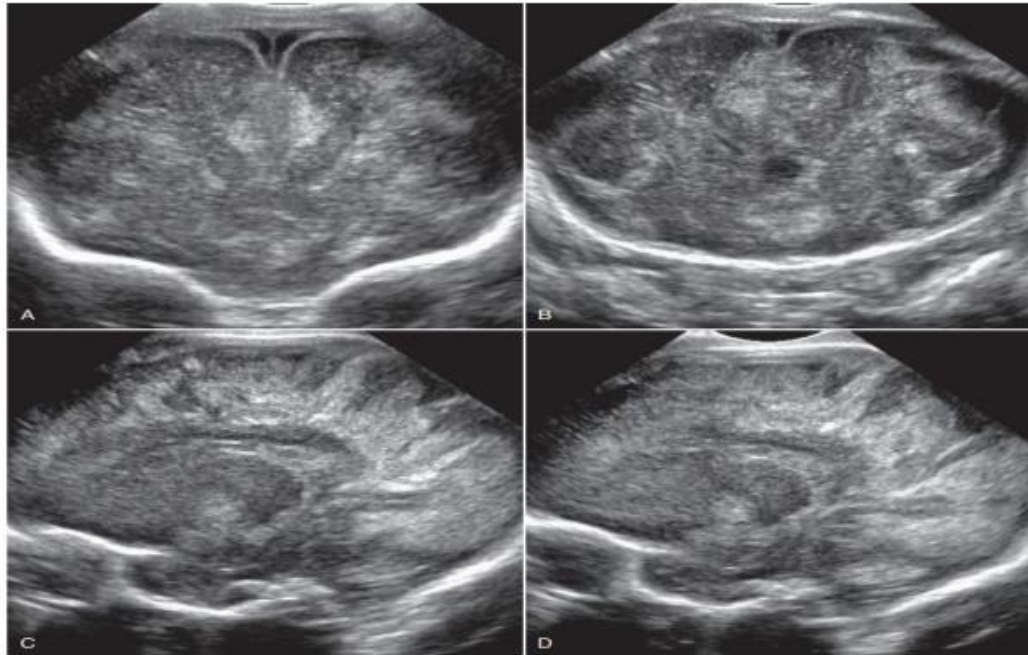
2 Cerebral Edema; (A) And (B) Coronal sonograms; (C) and (D) sagittal sonograms. Severe cerebral edema has caused effacement and silhouetting of the sulci from acute, near-total intrauterine asphyxia after placental abruption. Diffuse increased echogenicity from edema obscures sulci. Ventricles are slit-like because of the severe edema [54].
